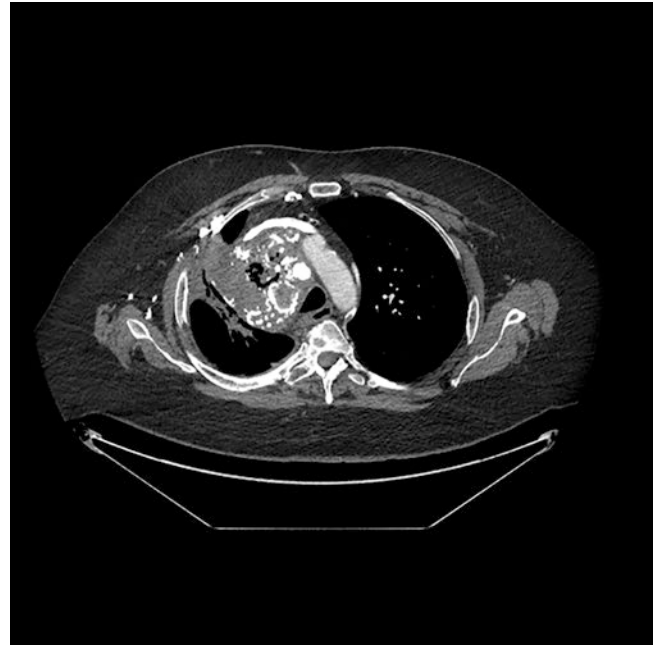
A large mass-like lesion with cavitation and calcification in the right upper lobe of a patient with nodular pulmonary amyloidosis on a computed tomography scan
